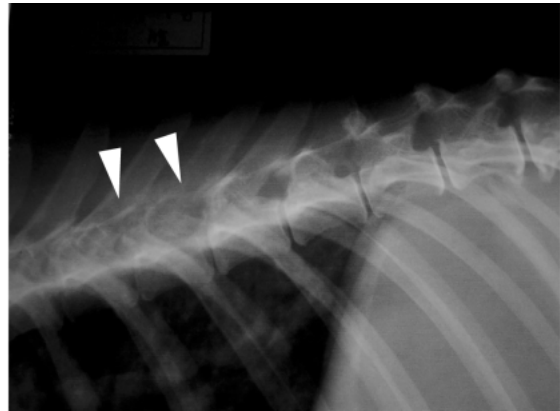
Left lateral thoracic radiograph demonstrating osteolytic lesions in the vertebral bodies and spinous process of 8th and 9th thoracic vertebrae (arrow heads).
